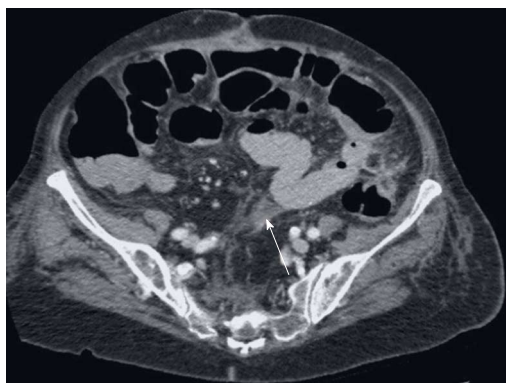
Transverse abdominal computed tomography scan as the gold standard with an inflammation of the mesentery at the height of the navel.
